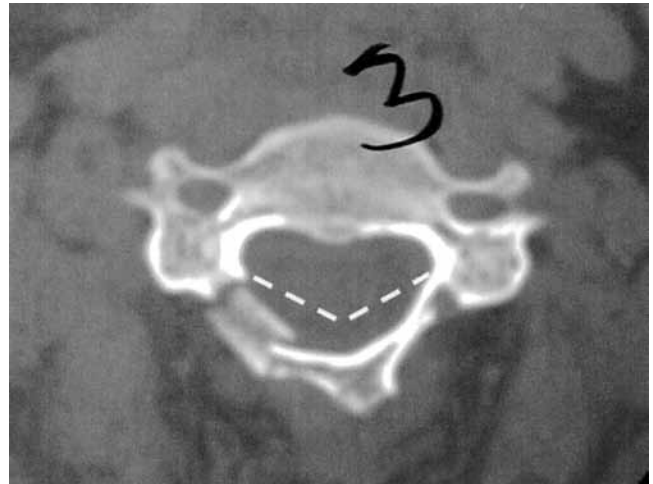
Postoperative axial CT showing positioned bone graft. Increased axial dimension at this level is shown with the dotted line corresponding to the initial dimensions of the cervical canal.
